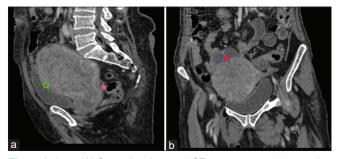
(a and b) Sagittal and coronal CT scan sections showing that the tumor came into contact with the bladder in the front and the lower rectum behind (a), and into contact with the slender handles above (b).
